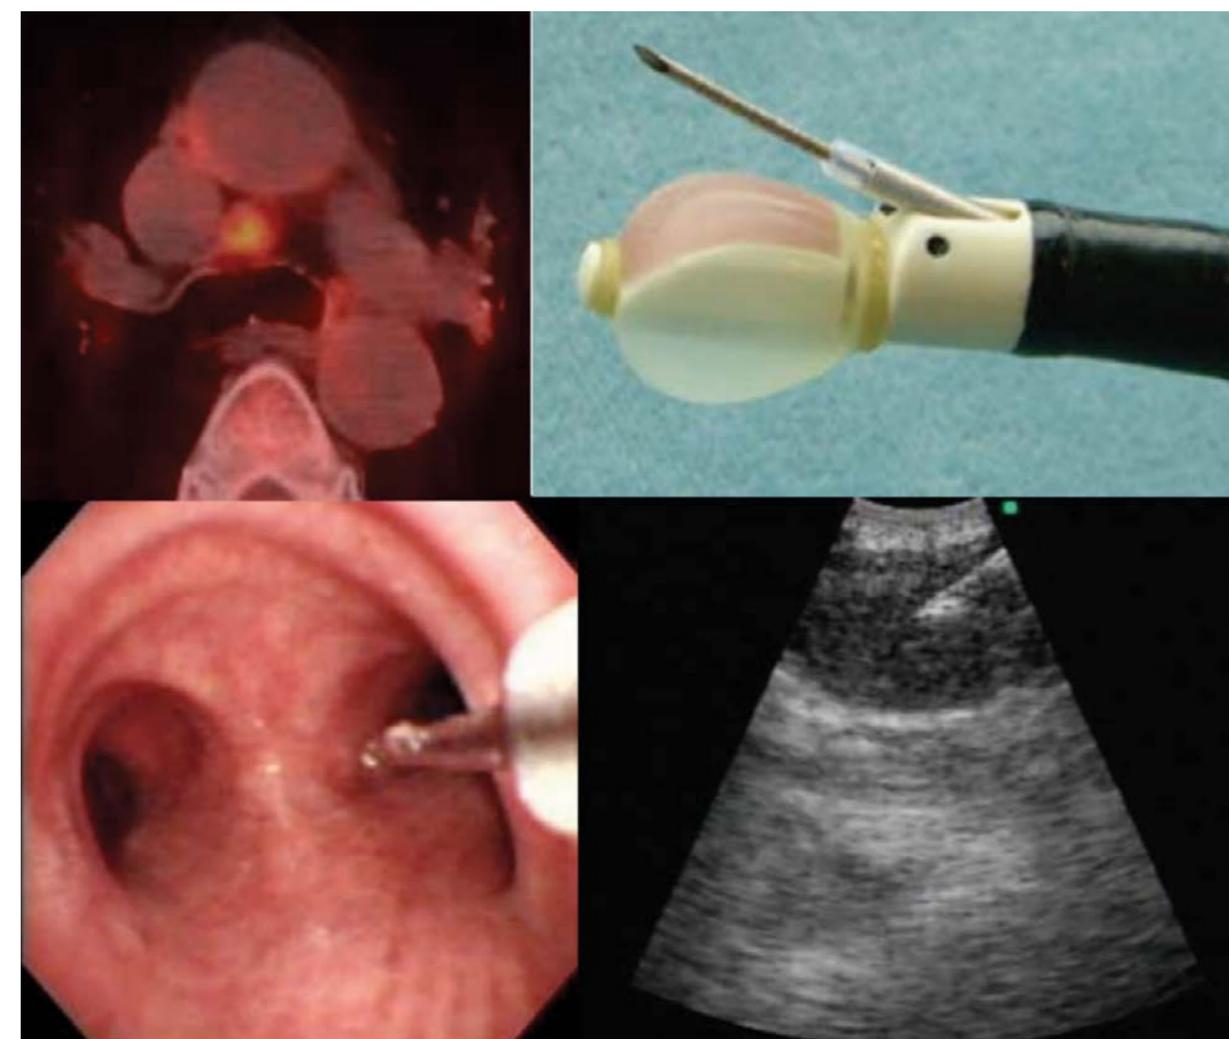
Convex Probe EBUS-TBNA, showing, clockwise from upper left, the lesion on CT scan, the tip of the probe, the passage of the probe into the bronchus and the ultrasound image.
